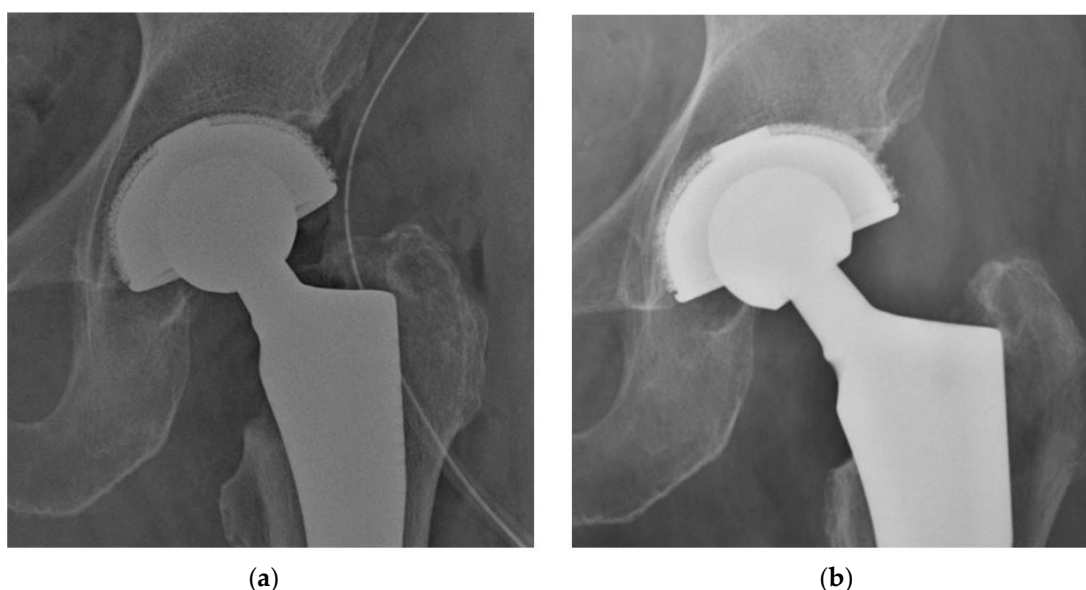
(a) Polar gap visible as a radiolucent area behind the acetabular cup dome in zone 1 and zone 2 in an immediate postoperative radiograph; this polar gap is due to the difference between the cup profile, which is polar-flatted, and the hemispherical profile of the acetabular reamers. (b) Polar gap filled through new bone formation within the first year.
